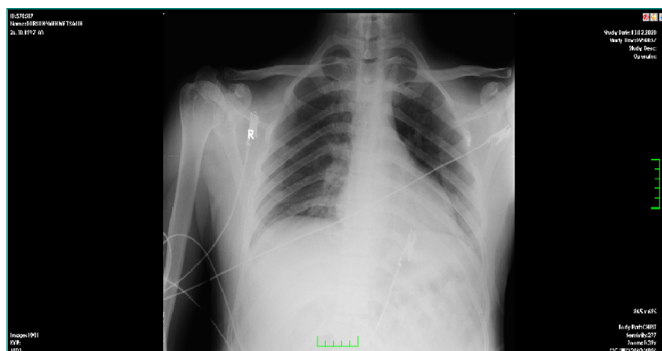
Postoperative half an hour PA chest X-ray.
